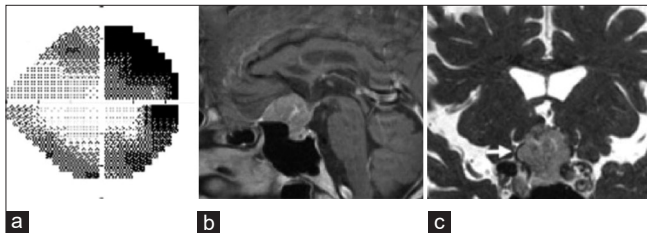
(a) Two months later, his visual acuity and field were aggravated. (b) Gadolinium T1-weighted image showing tumor growth with homogeneous enhancement two months later. Dural enhancement can also be seen. (c) Fast imaging with steady-state acquisition revealed that the right optic nerve (white arrow) was compressed by the tumor.
